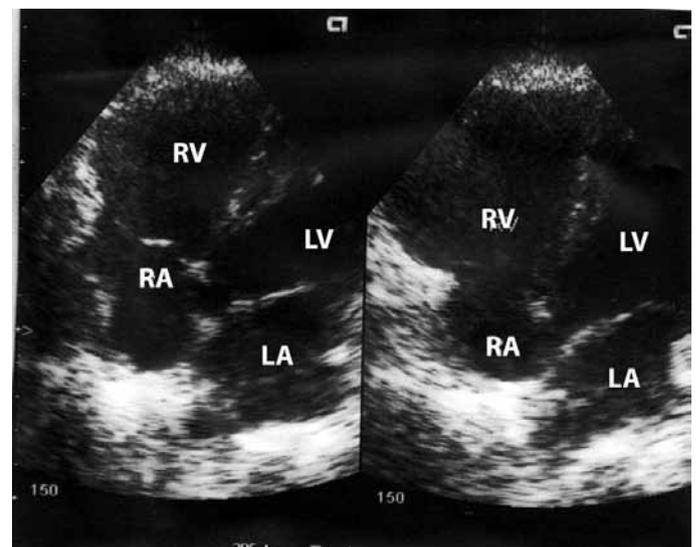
Transthoracic echocardiogram (4 chamber view) showing hypokinetic free wall of right ventricle.
